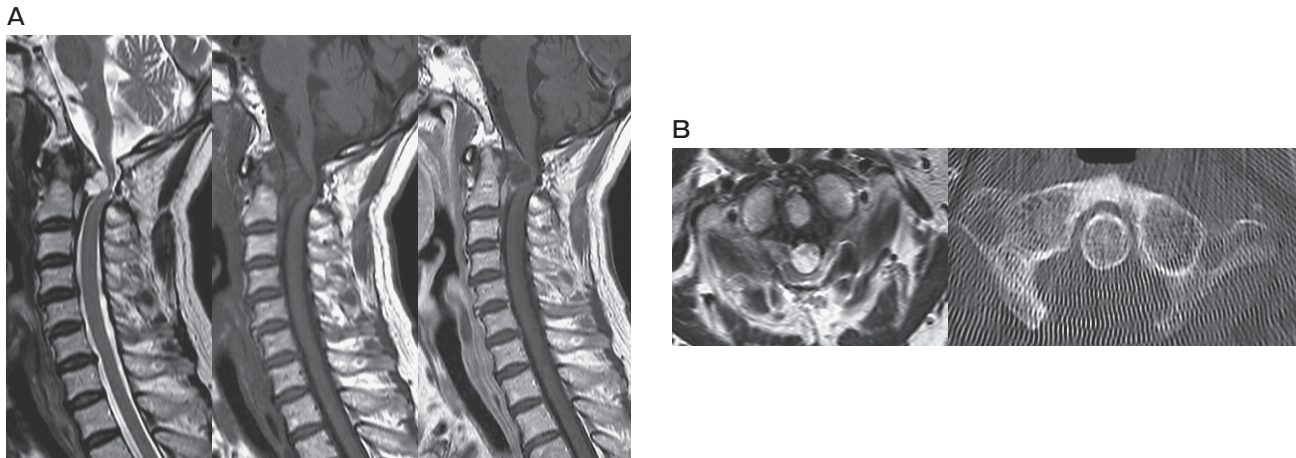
A, Sagittal view of T2- (*left*) and T1-weighted MRI (*middle*) before the revision surgery showing the pseudotumor with a multilocular cyst compressing the spinal cord and a high-intensity area within the spinal cord. T1-weighted MRI with gadolinium (*right*) shows peripheral enhancement of the mass; B, Axial view of T2-weighted MRI before the revision surgery (*left*) showing the pseudotumor with cyst severely compressing the spinal cord. Axial view of the plain CT (*right*) showing a defect of the arch of the atlas after the C1 laminectomy.
